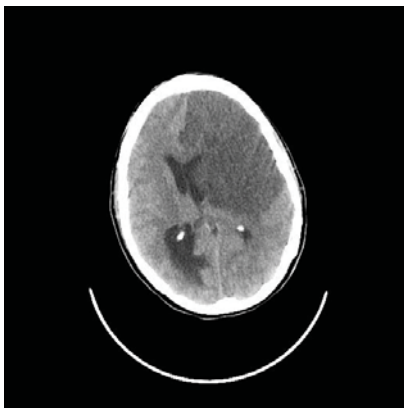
Cranial CT performed 24 hours ago (axial section): a greater hypodensity is observed in the territory of the MCA and the anterior cerebral artery on the left side in relation to infarction in the subacute phase, currently passing a greater subfalcine herniation and uncal herniation with dilation of left temporal horn and effacement of perimesencephalic cisterns.
